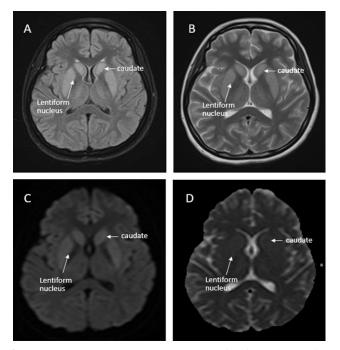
The magnetic resonance imaging (MRI) of the brain (A: T1-weighted showed bilateral hyposignal intensity, B: T2-weighted showed bilateral hypersignal intensity, C: diffusion-weighted imaging (DWI) showed high signal intensity D: apparent diffusion coefficient (ADC) showed low signal intensity) at caudate and lentiform nuclei.
